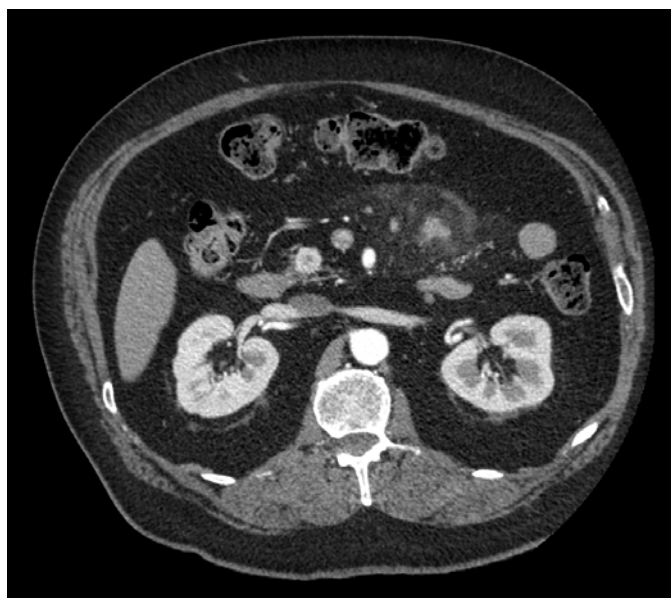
Transverse i.v. contrast-enhanced CT in the arterial phase showing a hypervascular pancreatic NET (arrow) in the uncinate process of the pancreas.
